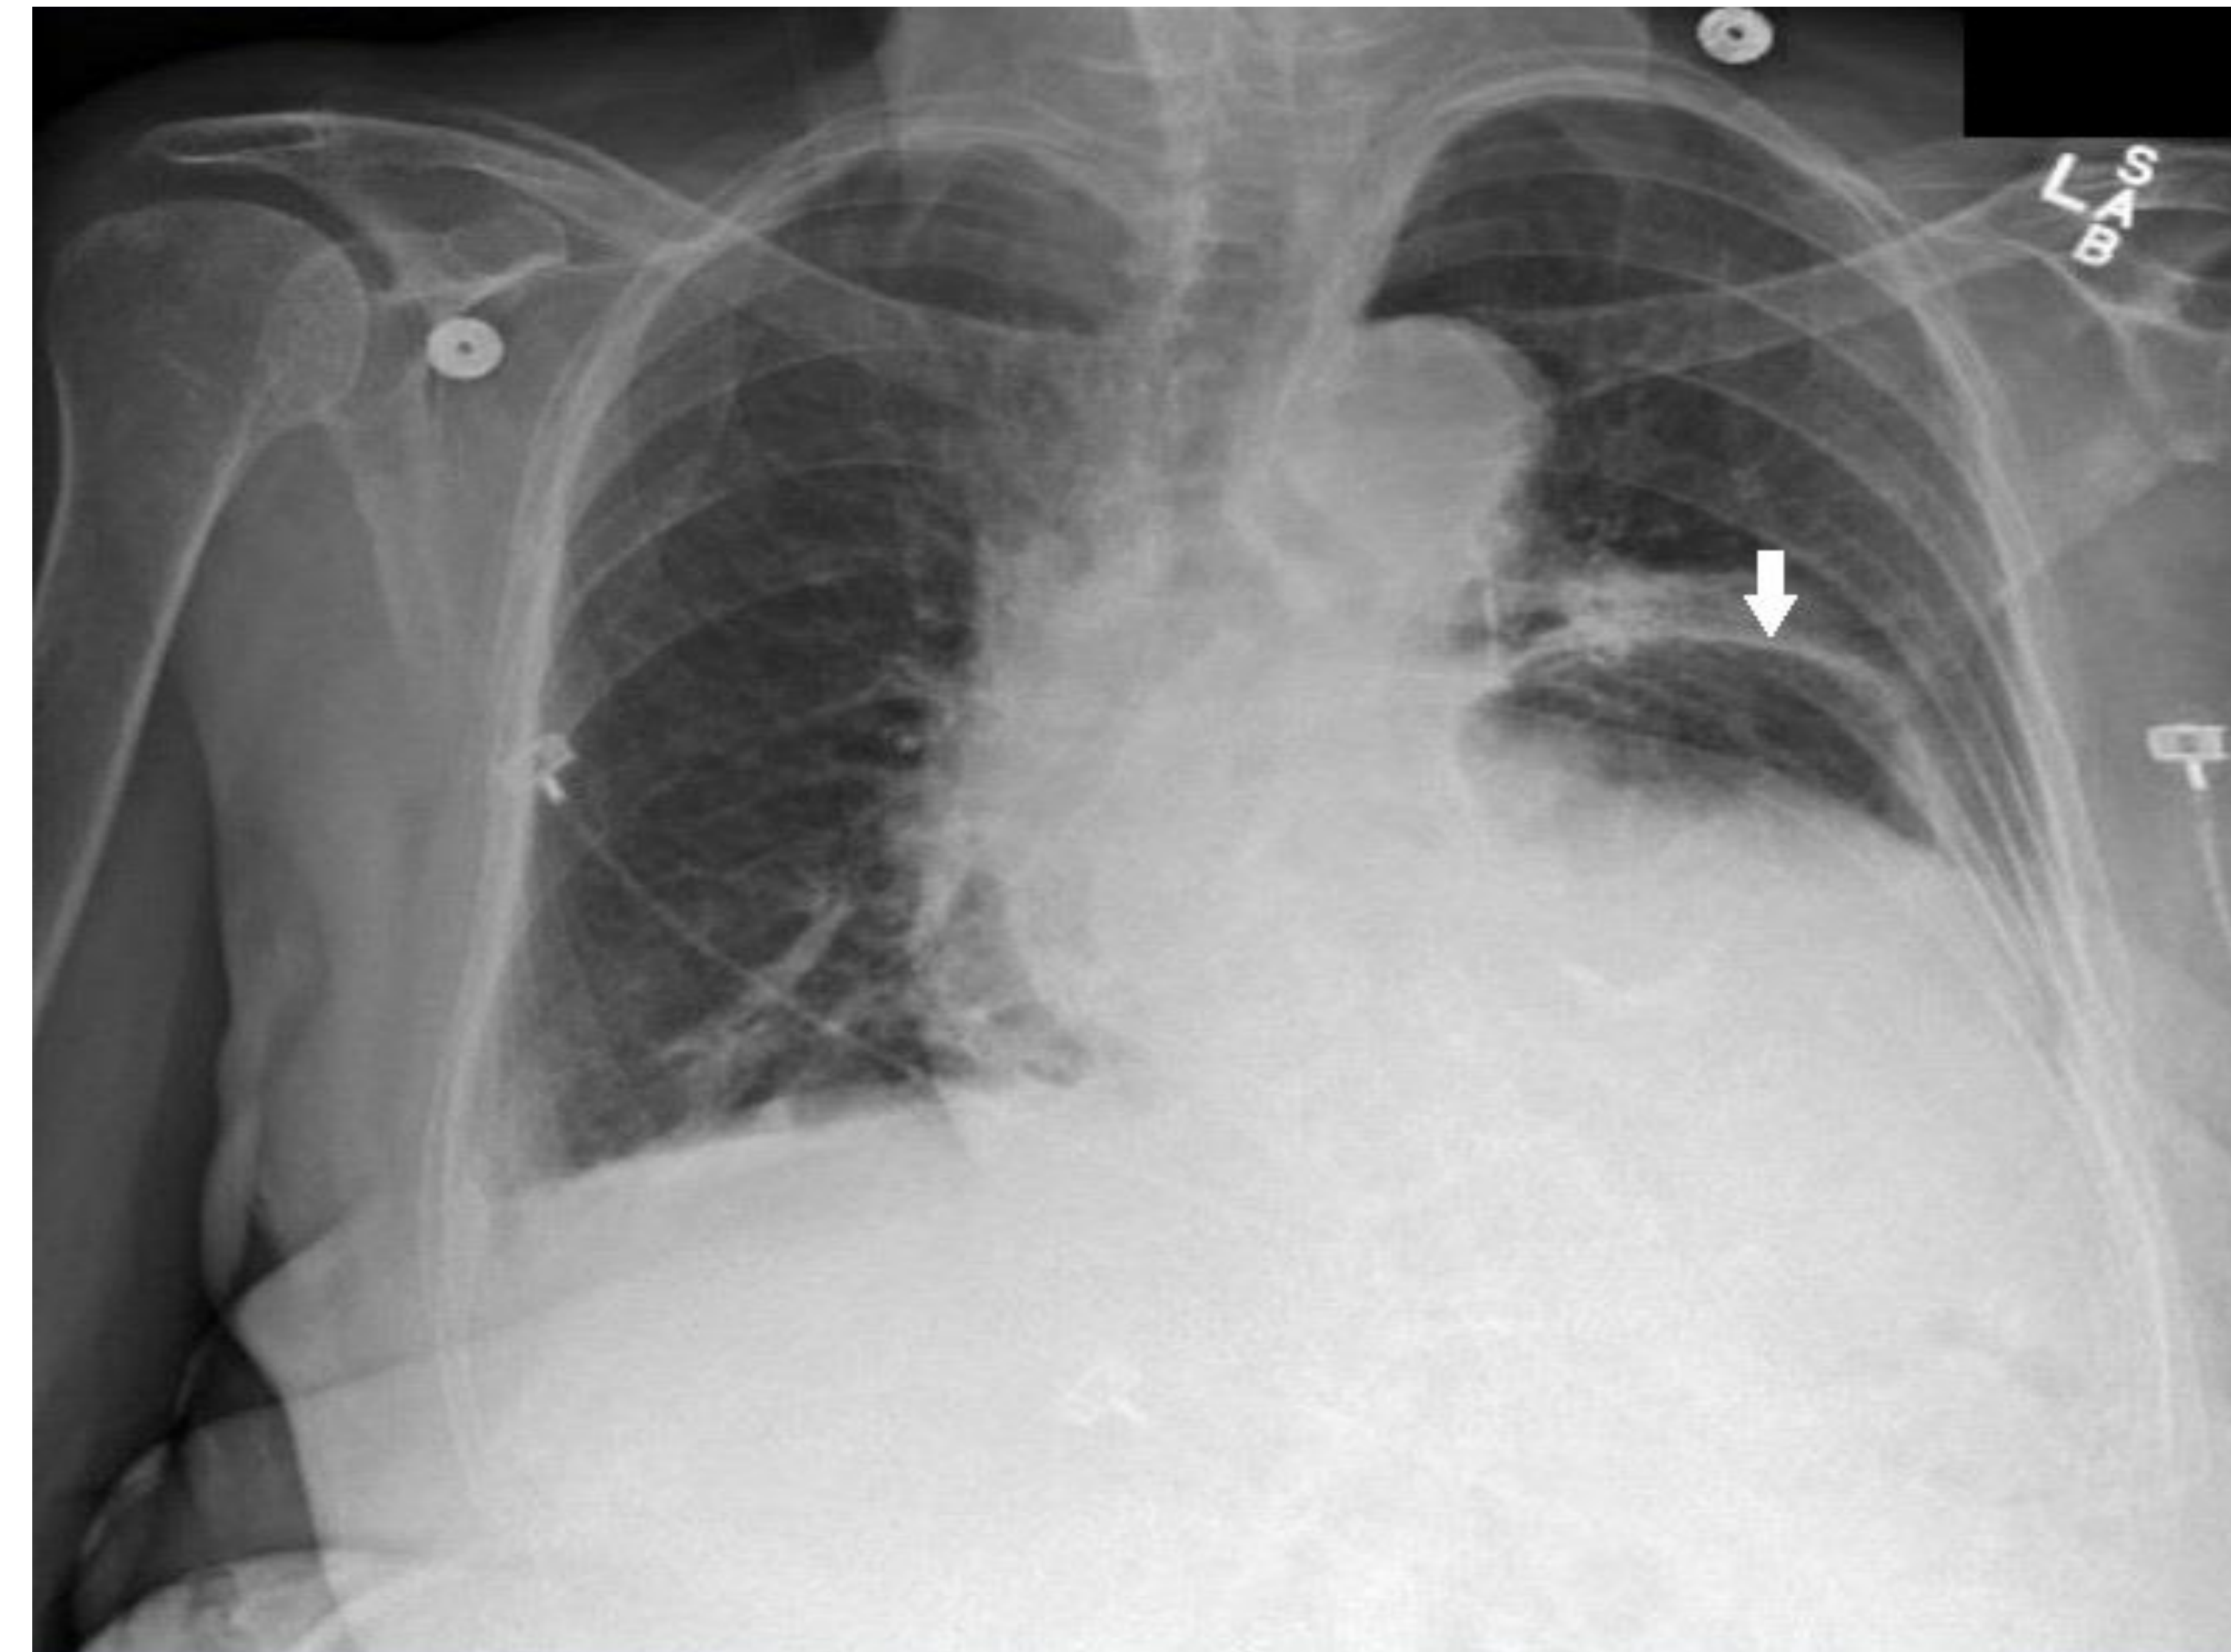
Chest X-ray obtained in the ED demonstrating a large Hiatal Hernia.
